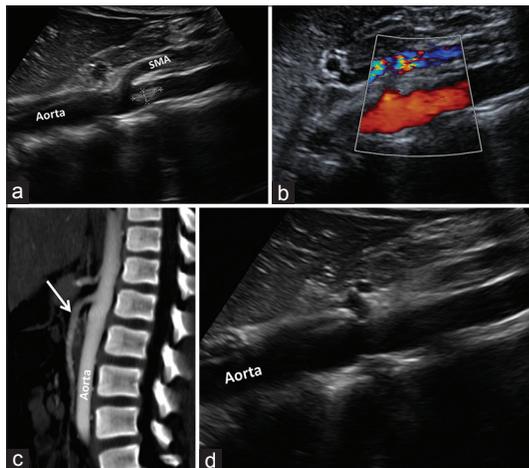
10-year-old boy with acute abdominal pain. (a) Sagittal grayscale sonographic image of the aorta shows an echogenic intraluminal filling defect (arrow) at the origin of the superior mesenteric artery (SMA). (b) Color Doppler image shows the normal flow pattern in the SMA with no definite mass lesion or intraluminal dissection flap. (c) Sagittal CT angiography reformatted image shows normal abdominal aorta and SMA (arrow) with no evidence of filling defect or dissection. (d) Sagittal sonographic image of the abdominal aorta without the SMA in the scan plane confirms no intraluminal or mural aortic abnormality.
